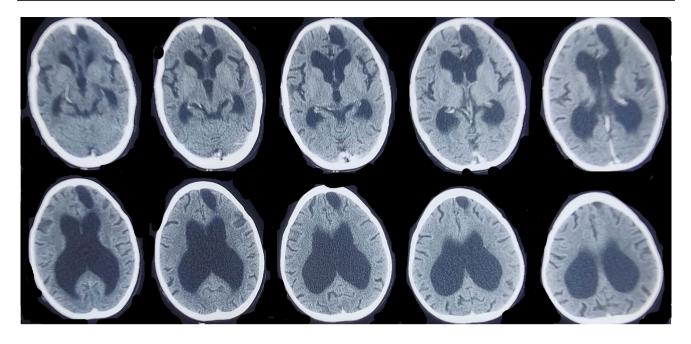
Follow-up CT at 3 months shows complete resolution of pneumocephalus with no change in ventricle size compared to post-op scan
